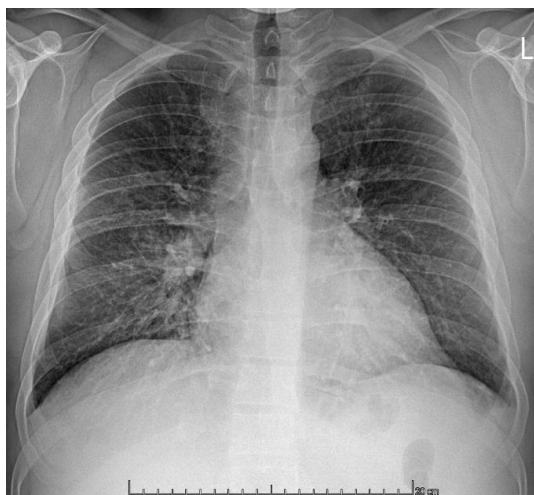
Chest radiograph. Pericardial inflammatory masses were found in middle-lower field of right lung.
